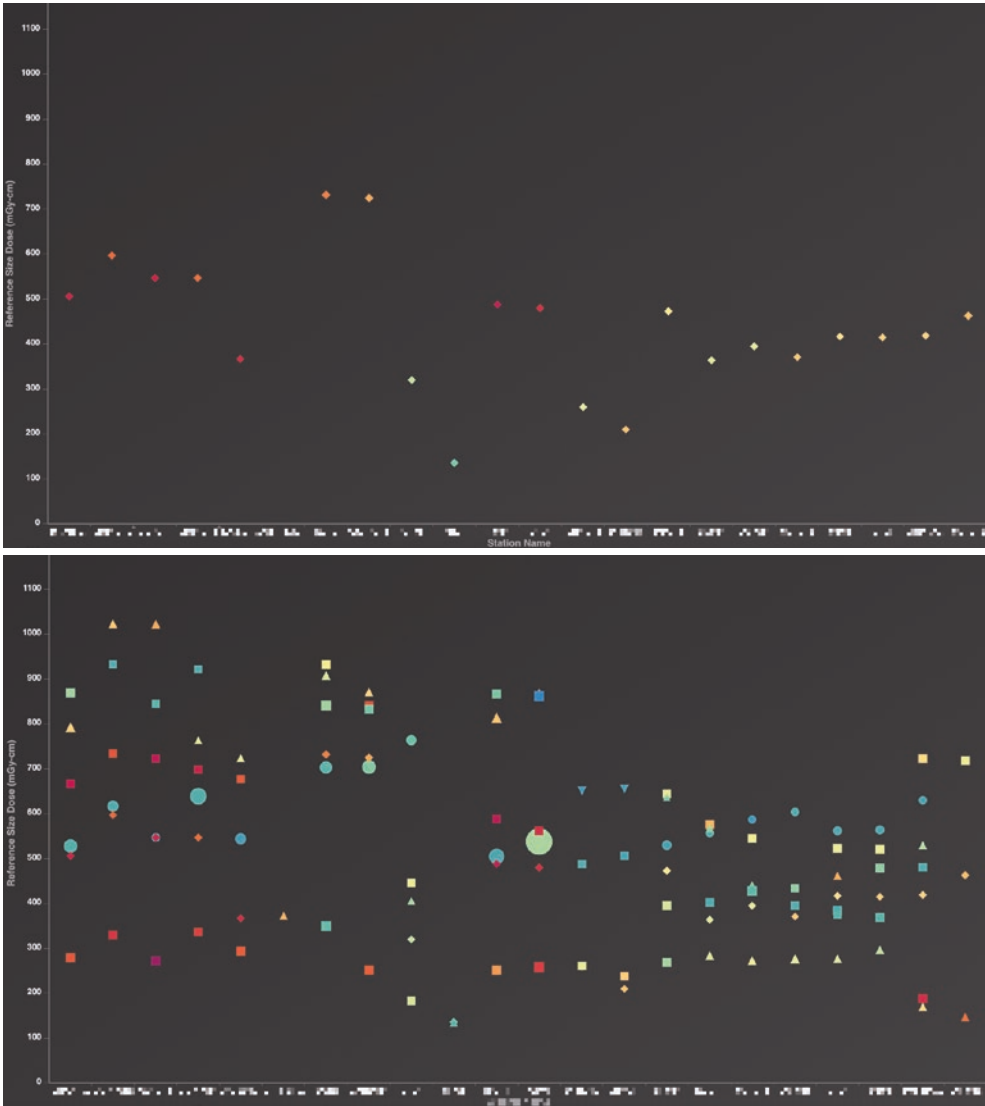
Plots of dose variances between different CT scanners for a given protocol (top) and across some protocols (bottom). Each point on this plot represents the performance of one protocol for the entire period studied.
